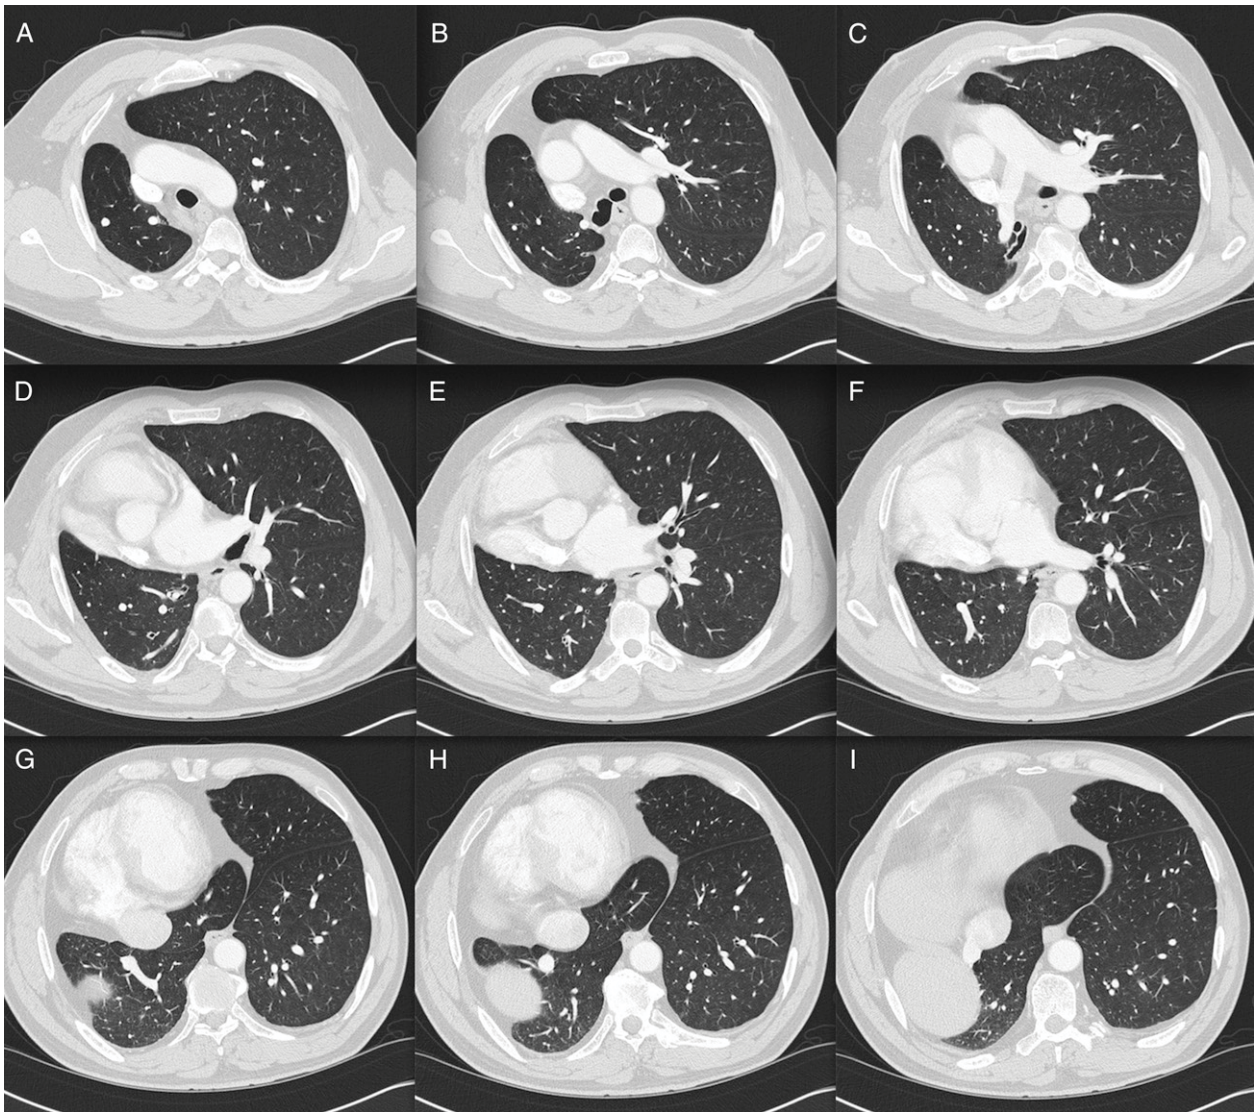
A-I, Serial transverse cuts of high resolution chest CT scan with contrast.
